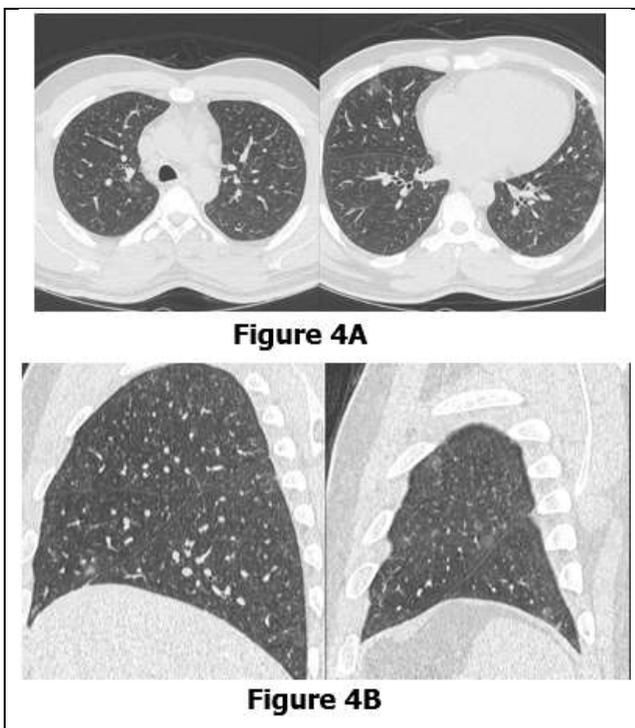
The axial (A) HRCT lung images show widespread ill-defined centrilobular nodules and opacities in both the lungs with few larger bronchocentric ground-glass opacities also seen in the right middle lobe and the lingula. The sagittal reconstructed (B) images show the diffuse lesions in both the upper and lower lobes.
